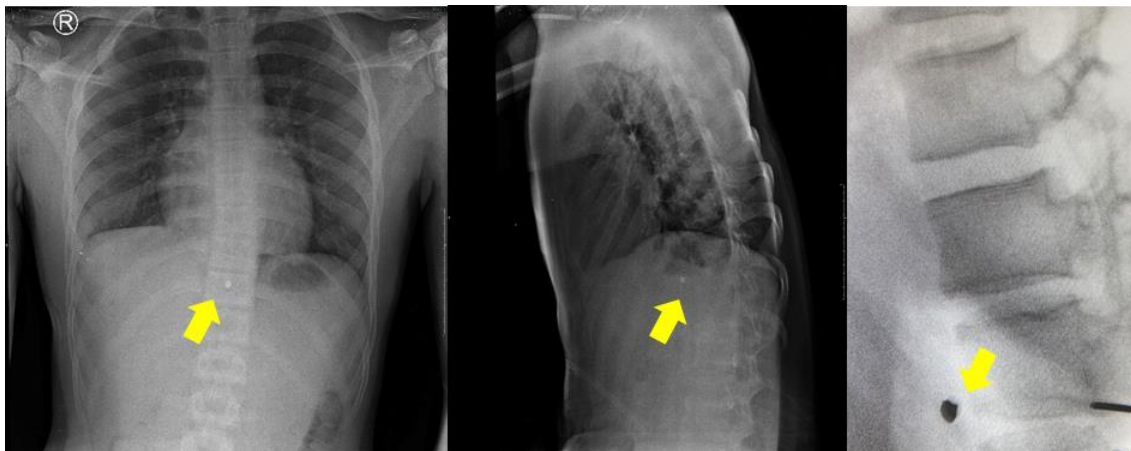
Anterior-posterior and lateral chest x-ray. Corpus allienum found in the thoracic 12 vertebrae region (yellow arrow)
